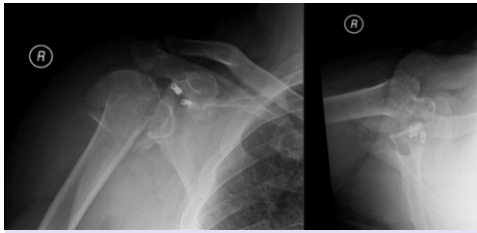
Pre-operative radiographs show the patient's proximal humerus fracture.
